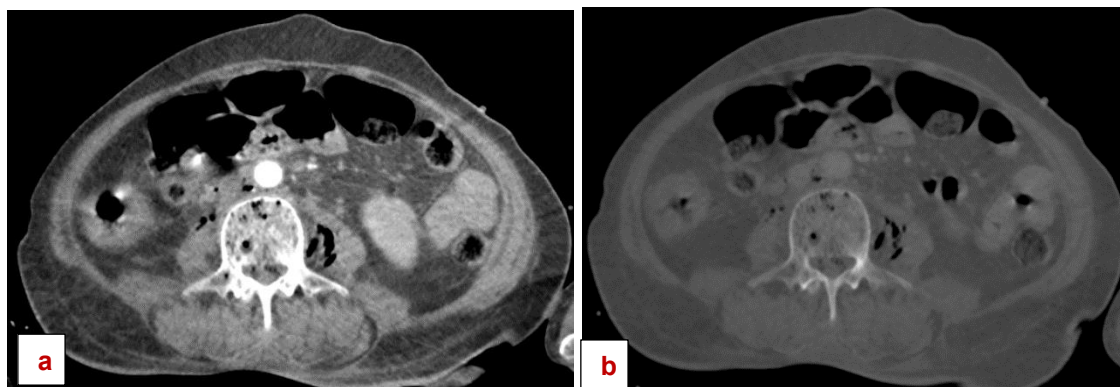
Abdominal CT in parenchymal (a) and bone windows (b) demonstrating air bubbles within the L4 vertebral body, extending to the psoas muscles, the interaortocaval space, and the laterocaval region.
